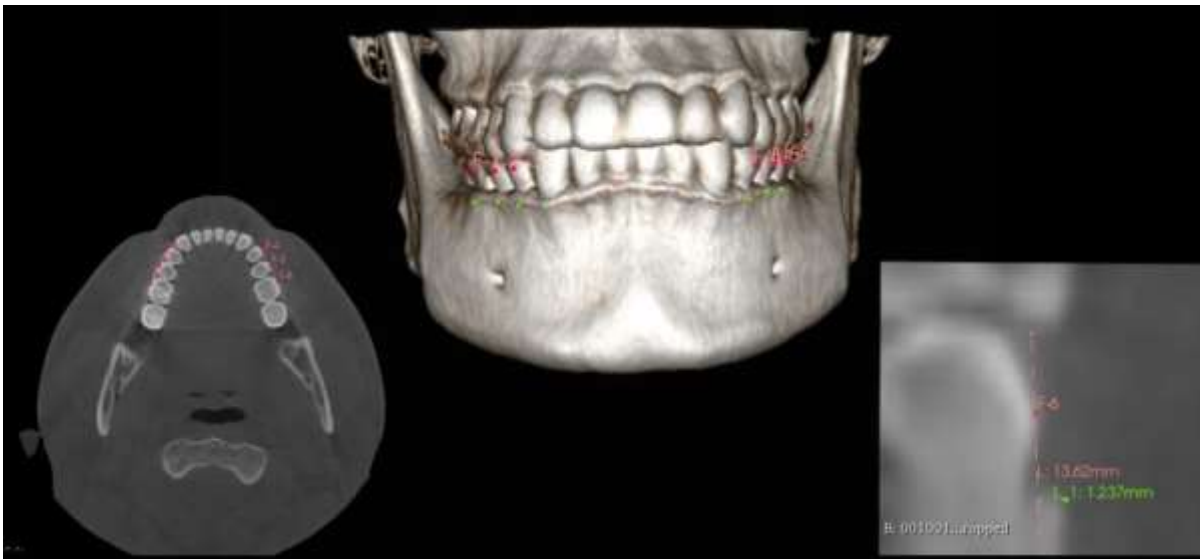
WALA border on CBCT, FA point pink; WALA point green.
